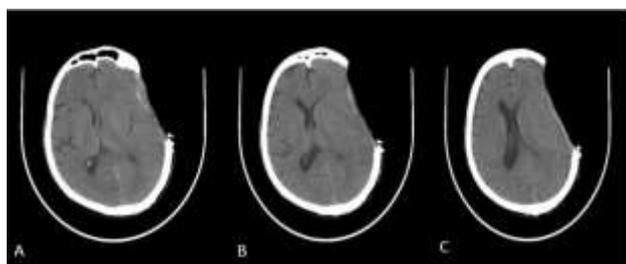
(A-C): Plain CT scan of brain showing sinking flap at craniectomy site with paradoxical brain herniation on right side.
